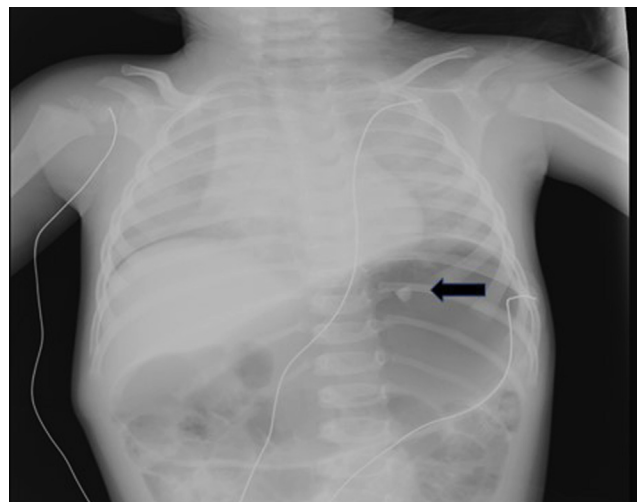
Chest and abdomen radiography showing a radiopaque foreign object in the stomach (arrow).
